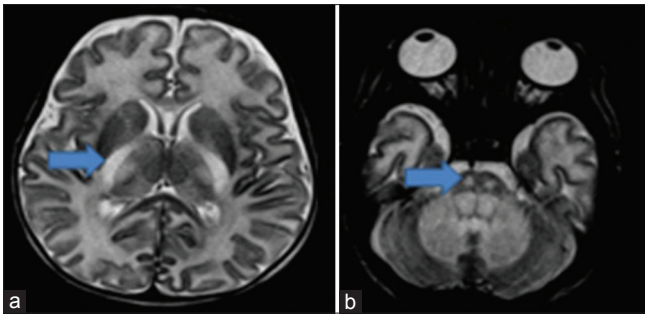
Seven-day-old newborn. Axial T2-weighted MR images shows bilateral symmetrical hyperintensities in posterior limb of internal capsule (blue arrow in Figure 3a), central cerebellar white matter, and in the corticospinal tracts (blue arrow in Figure 3b)
